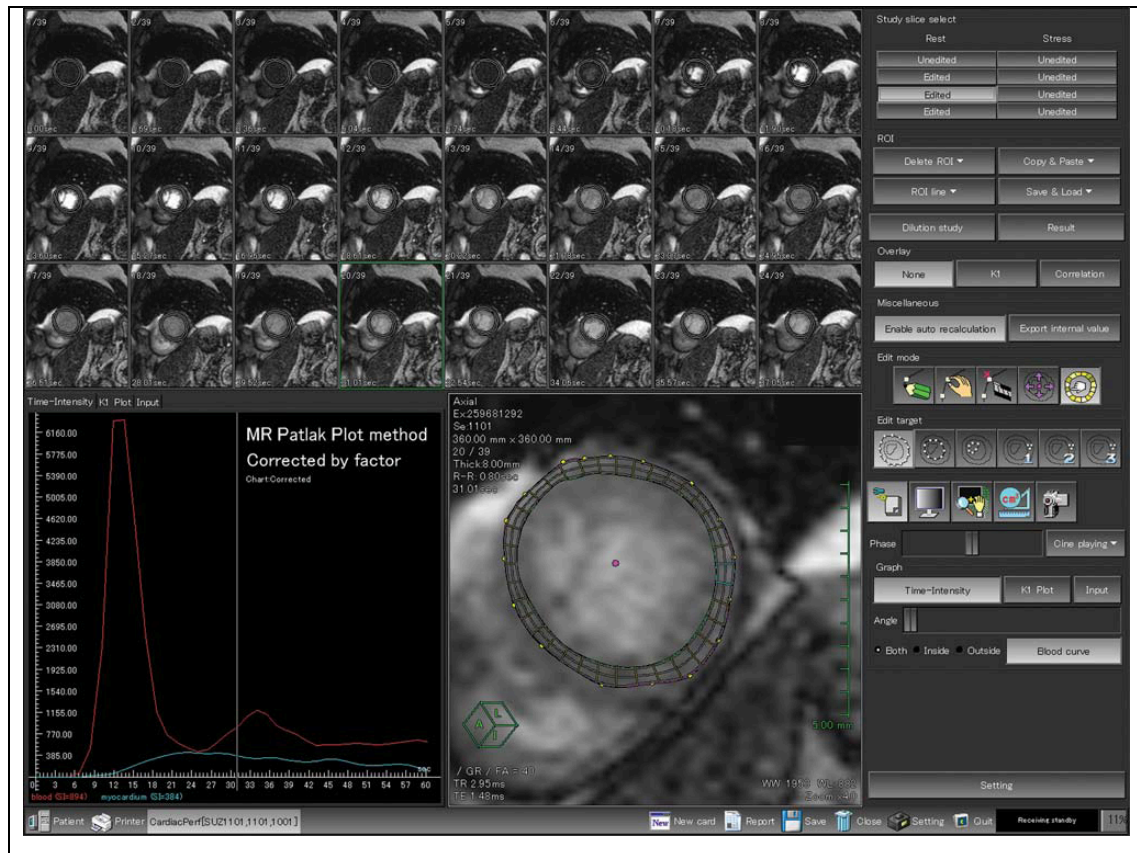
Quantitative analysis of myocardial perfusion magnetic resonance images using the Patlak plot method. Similar software was used for the quantification of myocardial blood flow in this thesis. Epicardial and endocardial contours of the left ventricular (LV) myocardium are manually determined to generate myocardial signal intensity (SI) curves. A region of interest is placed in the LV chamber to generate a blood SI curve. Patlak plot analysis is performed using blood input function and myocardial output functions [adapted from Kurita, Ishida et al. *EHJ* 2009]²⁹⁸.
